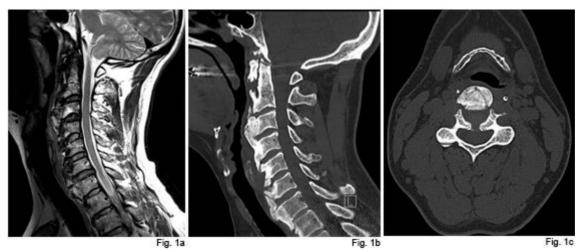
(1.5 column fitting): Pre-operative imaging for Patient 1 demonstrating C3-T1 cervical DISH involvement in a) sagittal MRI b) sagittal CT and c) axial CT imaging.
